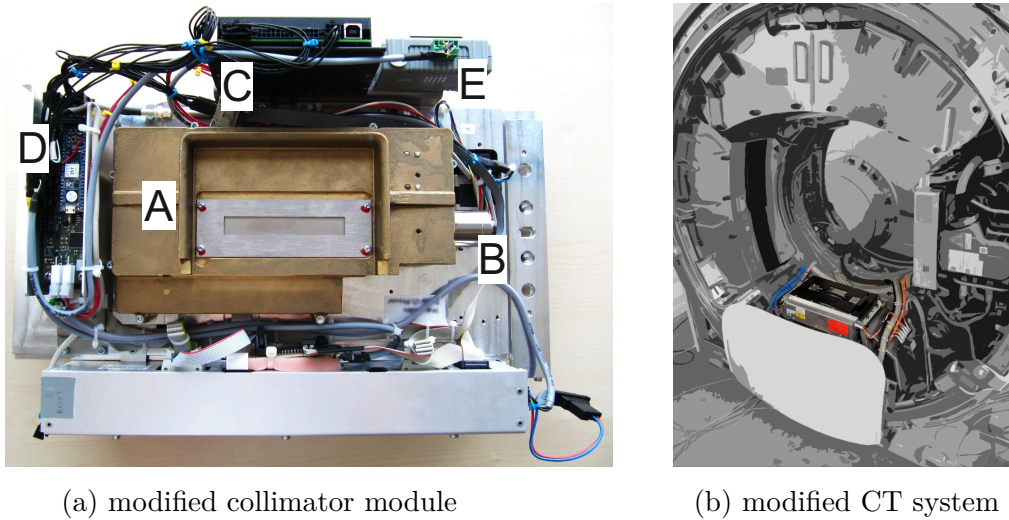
Integration of the z-sbDBA prototype into the clinical CT system. (a) The collimator box (A) that incorporates the z-sbDBA prototype (B), see Figure 2.2(d), is mounted on the collimator module of the CT system. The collimator module further carries the motor controller (C), the FPGA board (D), and the WLAN module (E). (b) The modified collimator module is installed (upside down) into the gantry of a clinical CT system, which can be closed after assembly. Some features are blurred to protect confidential details.
